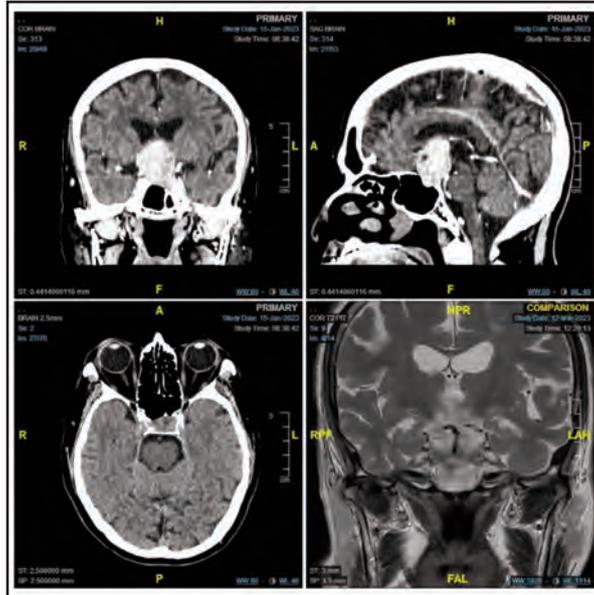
Initial CT brain and MRI images of well-defined extra-axial lesion in the pituitary fossa extending to the suprasellar region
